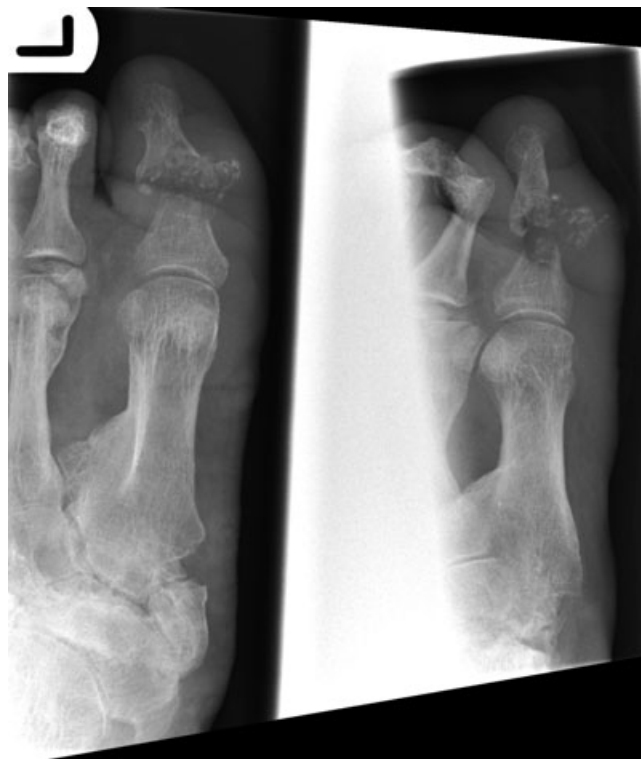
This radiograph displays two main abnormalities: (a) changes of osteomyelitis and septic arthritis involving the first metatarsophalangeal joint, with destruction of the distal first metatarsal and proximal area of the proximal phalanx of the great toe; and (b) chronic changes of Charcot neuroarthropathy in the first cuneiform/metatarsal area.
